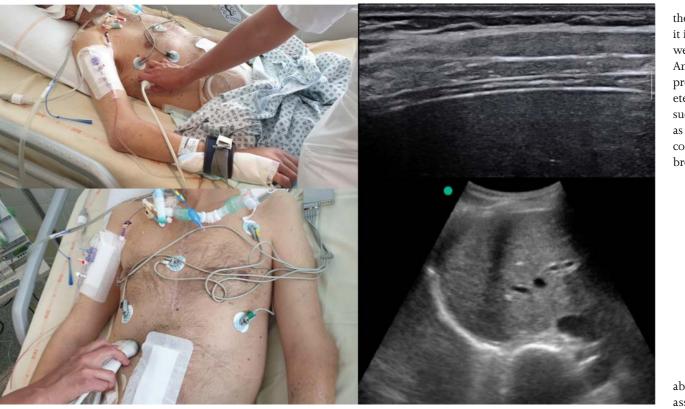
Left: position of the probe for the intercostal approach (up) and the subcostal approach (down). Right: Ultrasound images of the diaphragm using the intercostal approach (up) and the subcostal approach (down).
